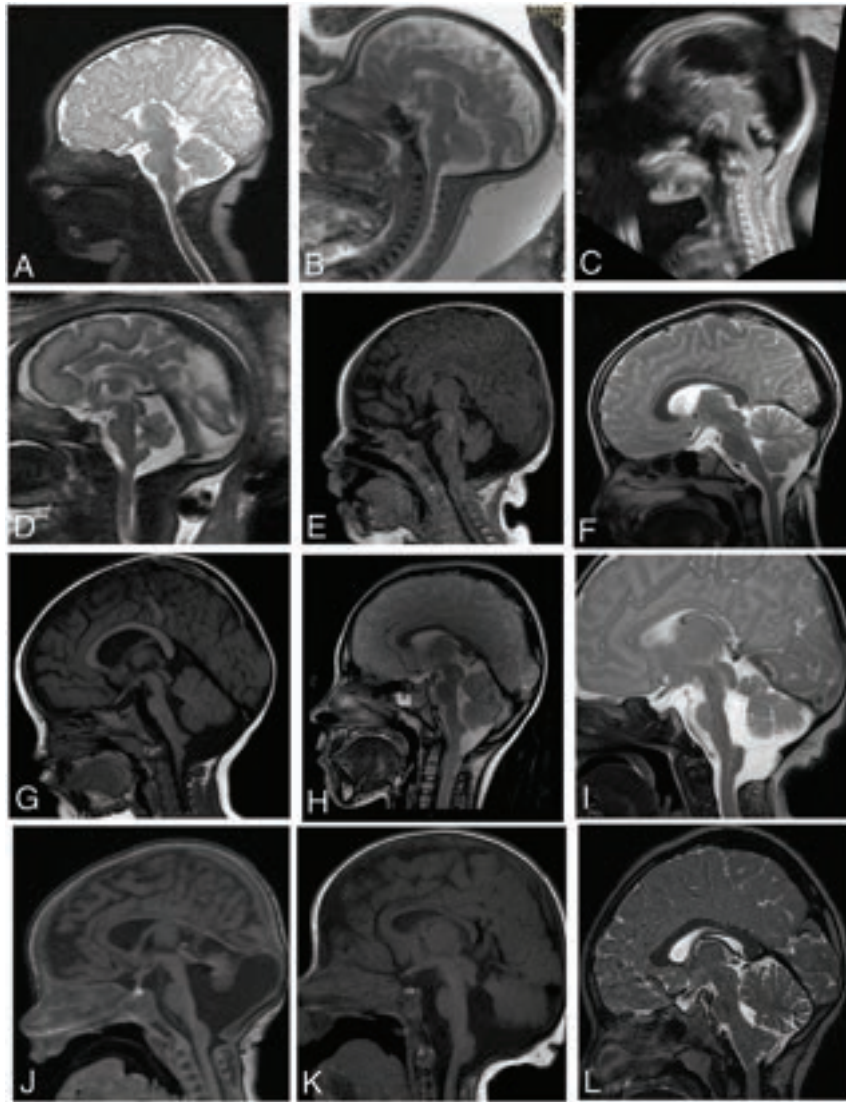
MR imaging and ultrasound showing the medullary cap in 12 patients, midsagittal view. A, Patient 1; B, Patient 2; C, Patient 3; D, Patient 4; E, Patient 5; F, Patient 6; G, Patient 7; H, Patient 8; I, Patient 9; J, Patient 11; K, Patient 12; L, Patient 13. Of note, patient 10's MR imaging is separately shown in the Online Supplemental Data.
